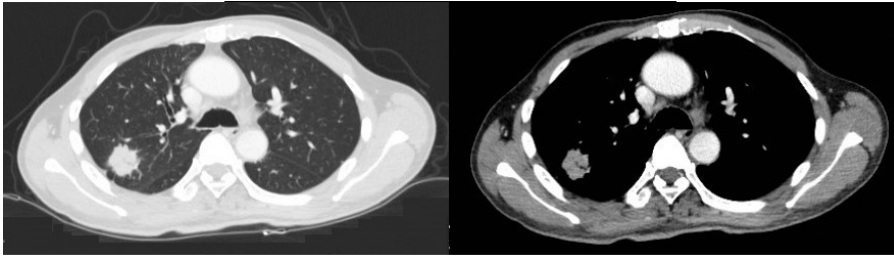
Preoperative pulmonary CT revealed a right pulmonary nodule
